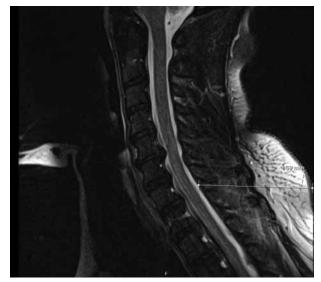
Example of midline cut of sagittal MRI image used to obtain depth measurement.
